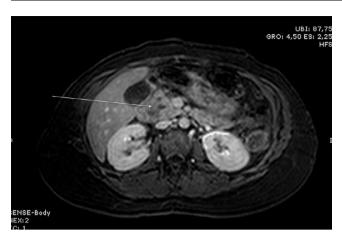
MRI image (sequence T1) showing a hypointense cystic lesion in the head of the pancreas.
